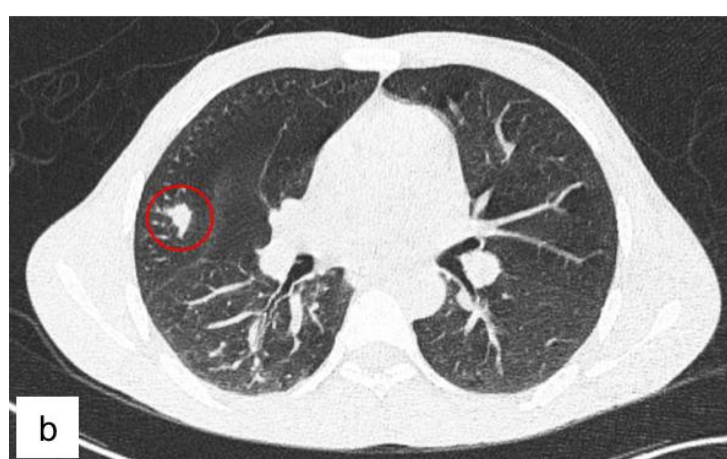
a) CT chest with multiple enlarged left axillary & subpectoral lymph nodes, some necrotic, up to 3.6 cm. b) CT chest with a 1.6 cm R upper lobe pulmonary nodule. c) CT abdomen with mild splenomegaly, span ~13.5 cm.
